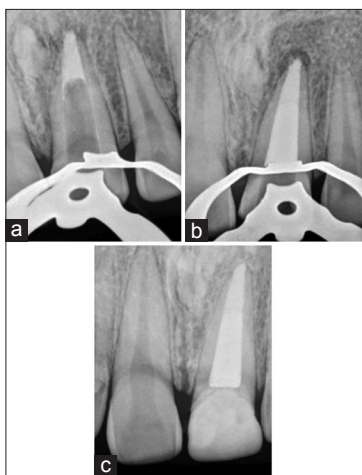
(a) Placement of 5 mm thick Biodentine™ apical plug against the placed matrix of platelet rich fibrin at the apex. (b) Radiograph after obturation of the tooth number 21 using injectable thermoplasticized gutta-perch. (c) 6-month follow-up radiograph presenting completely healed periapical lesion
